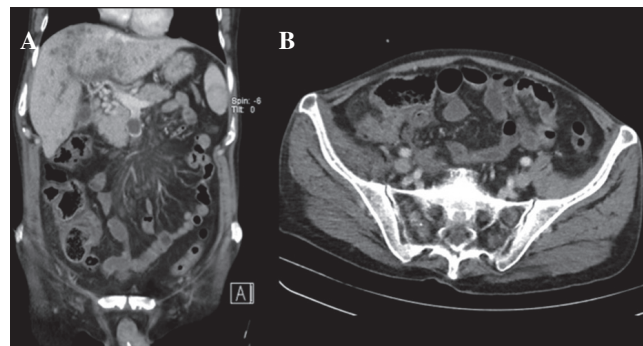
Initial CT: A. Inflammatory process in right iliac fossa suggestive of acute advanced appendicitis. B. Thrombosis of the superior mesenteric vein, liver abscesses.
